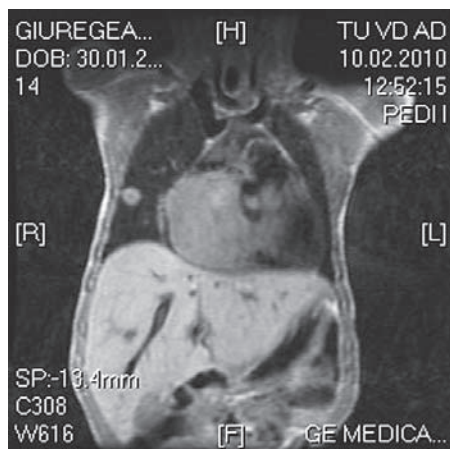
Cardiac MRI: giant cardiac tumor
